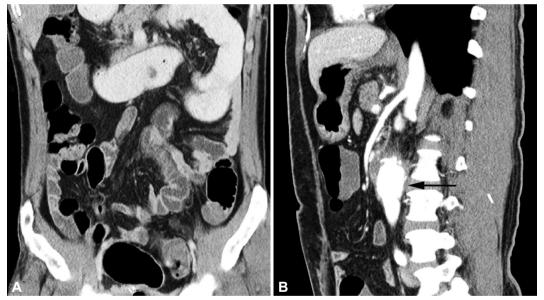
Computed tomography (CT) findings. (A) The sagittal CT scan during arterial phase of contrast enhancement shows focal thickening and irregularity of the aortic wall, but not direct extravasation of contrast material. (B) On the delayed coronal CT scan obtained 4 minutes after the initial contrast injection shows markedly dilated proximal small bowel loops (black arrow) filled with high density of fluid suggesting active bleeding to the bowel lumen.
